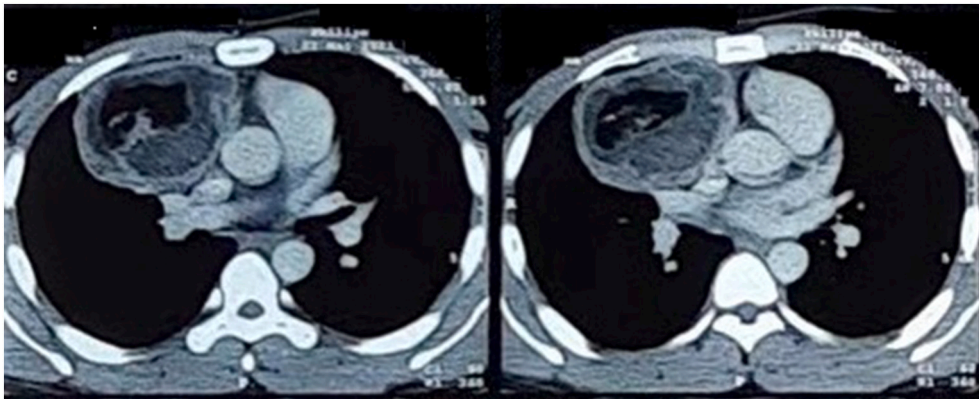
Thorax CT scan showed a mass in the right mediastinal of 8.7×6.7 cm. Characteristic mass included thick-walled cysts with fat, solid, and calcified components.
